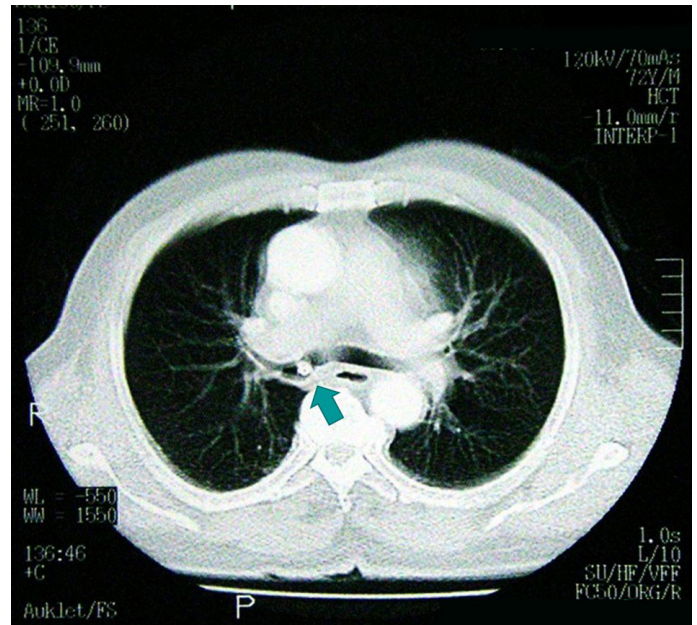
Chest computed tomography scan showing a mass lesion (arrow) in the right main stem bronchus.
